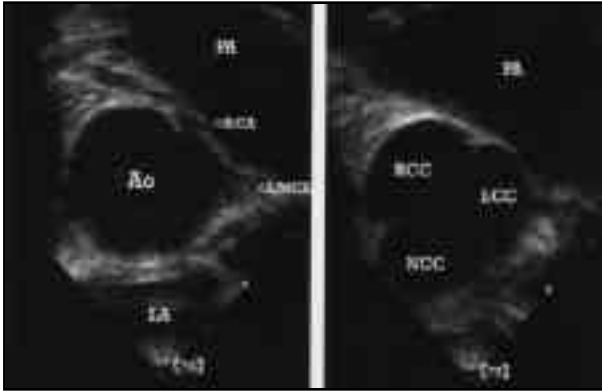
(A) Transesophageal echocardiographic image at mid-esophagus in short axis view at the level of aortic sinuses showing the three sinuses and the origin of the right coronary artery (RCA) from the left aortic sinus. Note the proximity to the anterior commissure.
